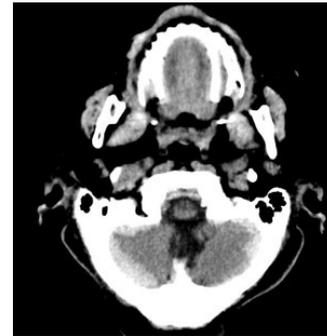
Non-contrast axial CT scans showing bilateral subdural haematomas, more pronounced on the right
